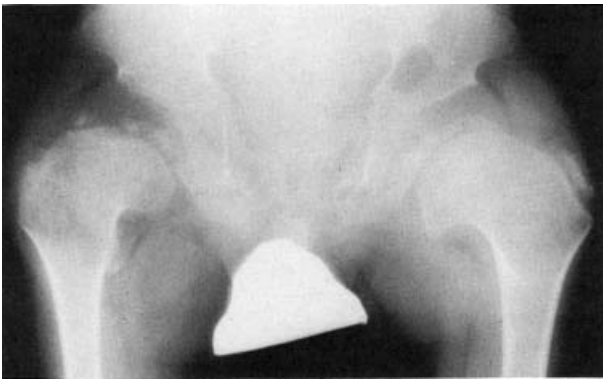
Radiograph of the hips and pelvis of a 12-year-old child with Kniest dysplasia. The capital femoral epiphyses are flat and fragmented. The femoral necks are wide and dysplastic. There is a coxa vara deformity of the hips.
